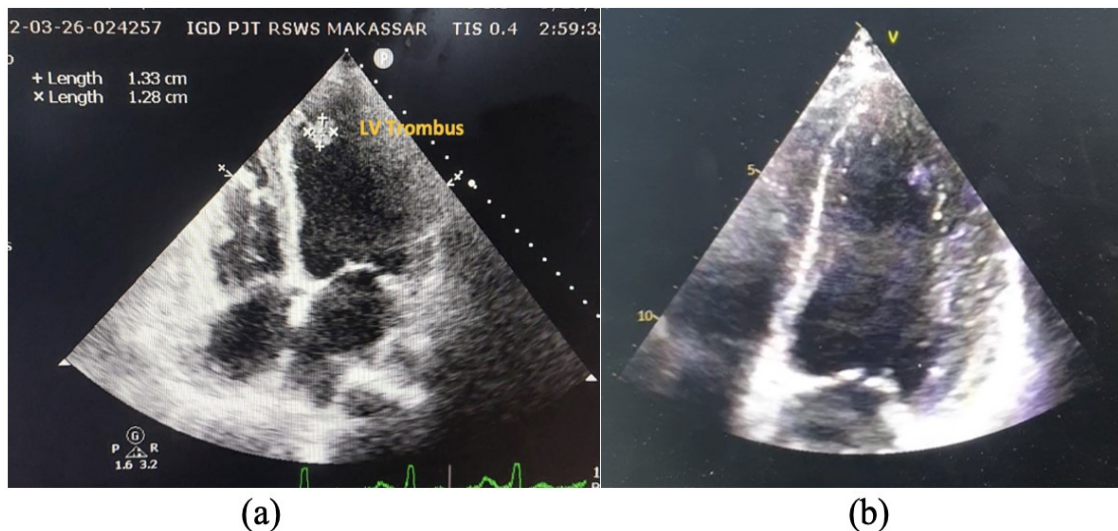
Transthoracic echocardiography (a) when patient 1st came, (b) after three months follow up.
